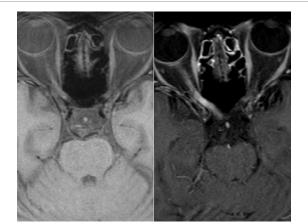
Extent of Eye Involvement in NMO. T2 (left) T1 (right) weighted MRI axial view of the orbits with thin cuts revealed atrophy of the left optic nerve and diffuse contrast enhancement of the right optic nerve, the right and middle portion of the optic chiasm, and the anterior aspect of right optic tract compatible with acute right optic neuritis.
